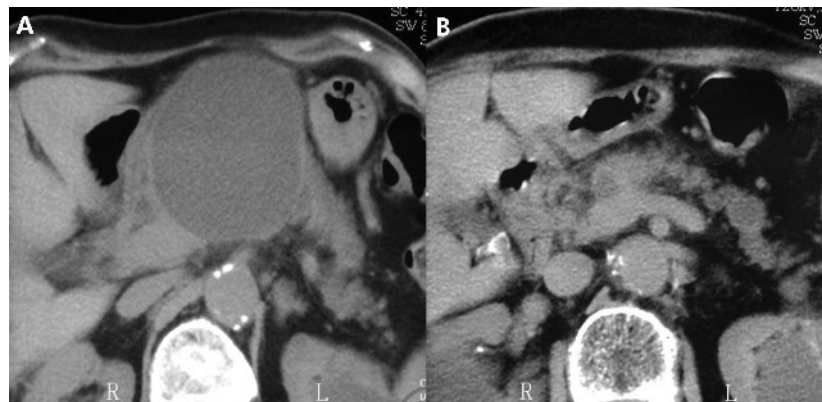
(A) Computed tomography scan showing an 8 cm pancreatic body cyst. (B) Cyst regression at six months after lavage with povidone iodine.
